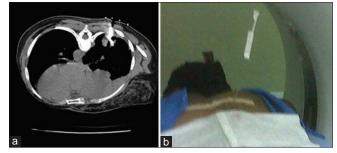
(a) Prone chest CT scan with trucut needle seen entering and within pulmonary lesion (b) patient placed within Gantry with Trucut Needle positioned between the markers on the skin of patient before performing biopsy
